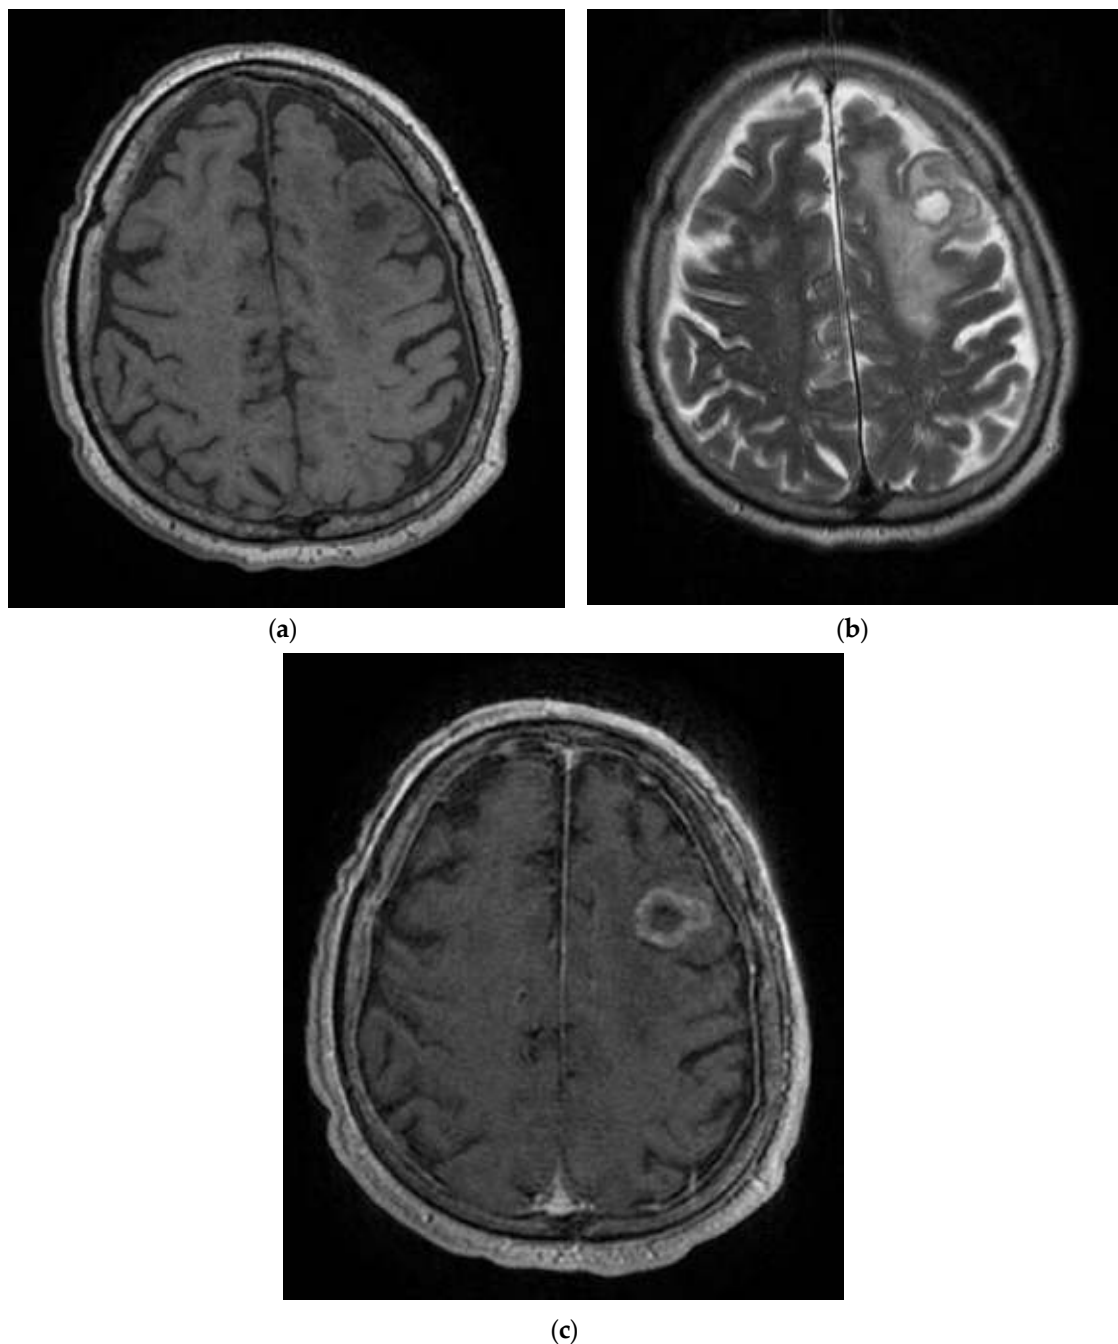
MRI T1 (a), T2 (b), and T1 sequence with contrast injection in the Case 7 patient (c) show solid-cyst mass (a,b) with ring-shaped peripheral gadophilia (c) and extended perilesional edema (b), disposed in the middle-left subcortical area. These pathological images are suggestive of a left-frontal expansive lesion, most likely meaning a secondary determination.
